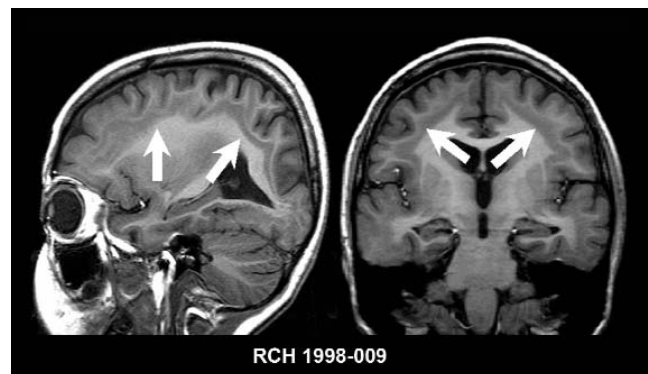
Imaging features of subcortical band heterotopia. Sagittal (left) and coronal (right) T1-weighted MRIs showing typical features of subcortical band heterotopia with bilateral, symmetric band of tissue with identical signal to cortical gray matter interspersed in the subcortical white matter between the normal cortex and the lateral ventricle. MRI, magnetic resonance imaging
